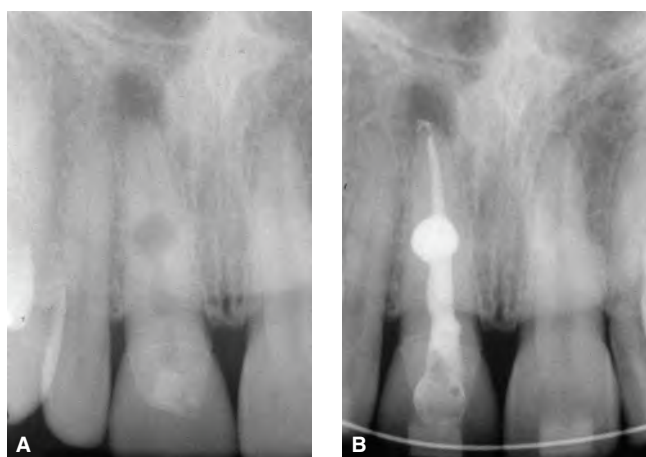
Internal root resorption. A. Radiograph showing the typical uniform radiolucency of internal resorption in the middle of the root of the left maxillary incisor. B. The area of internal resorption has been filled with softened gutta-percha and sealer. (Courtesy of Dr. Steven G. Morrow, Loma Linda, CA.)
